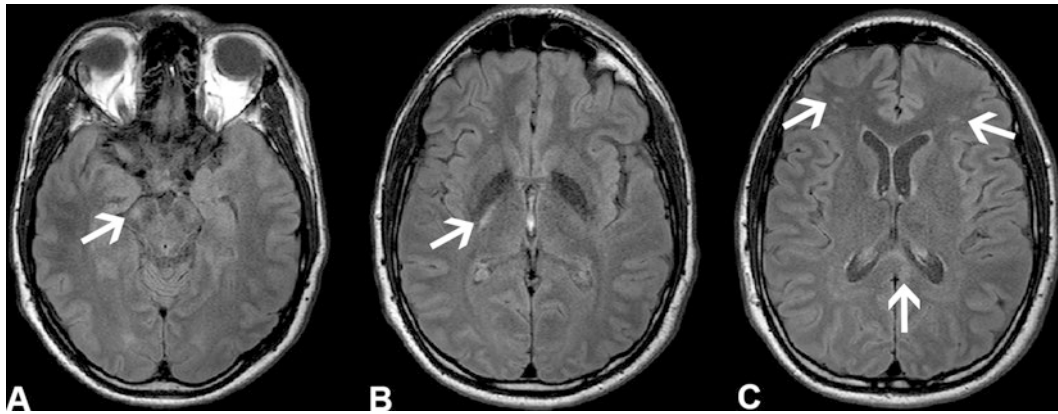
A 27-year-old male patient with moderate TBI due to a motorcycle accident. Axial FLAIR images show hyperintense lesions (arrows) in the lateral aspect of the right cerebral peduncle (a), right
